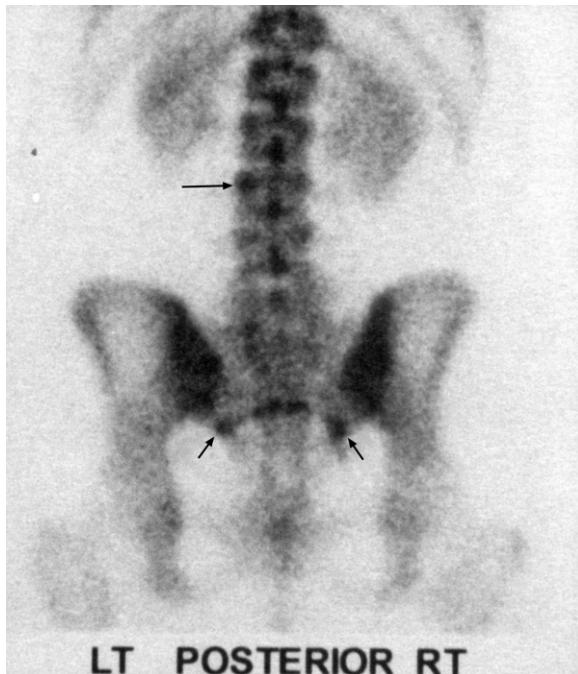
Dynamic Localized Bone Scan with SPECT image. Note the mildly increased uptake within the left L3 facet (long arrow) and the mild curvilinear uptake extending across the mid-sacrum (short arrows) at the level of the inferior sacroiliac joints.
